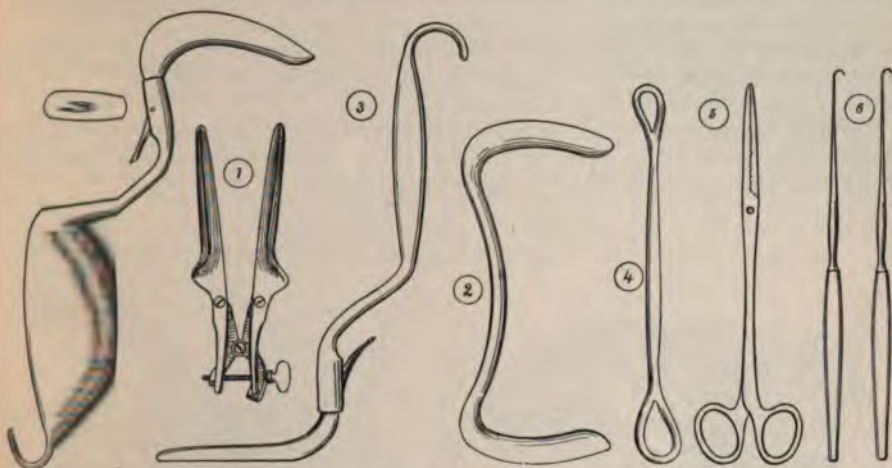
INSTRUMENTS FOR INDIRECT INSPECTION OF THE UTERUS.
